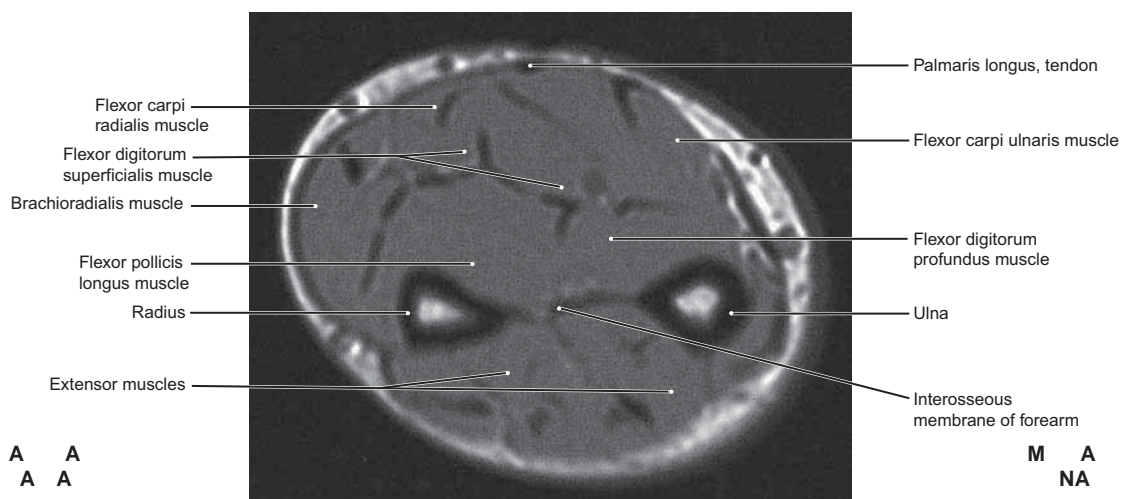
Transverse MRI Section through the Middle of the Forearm
